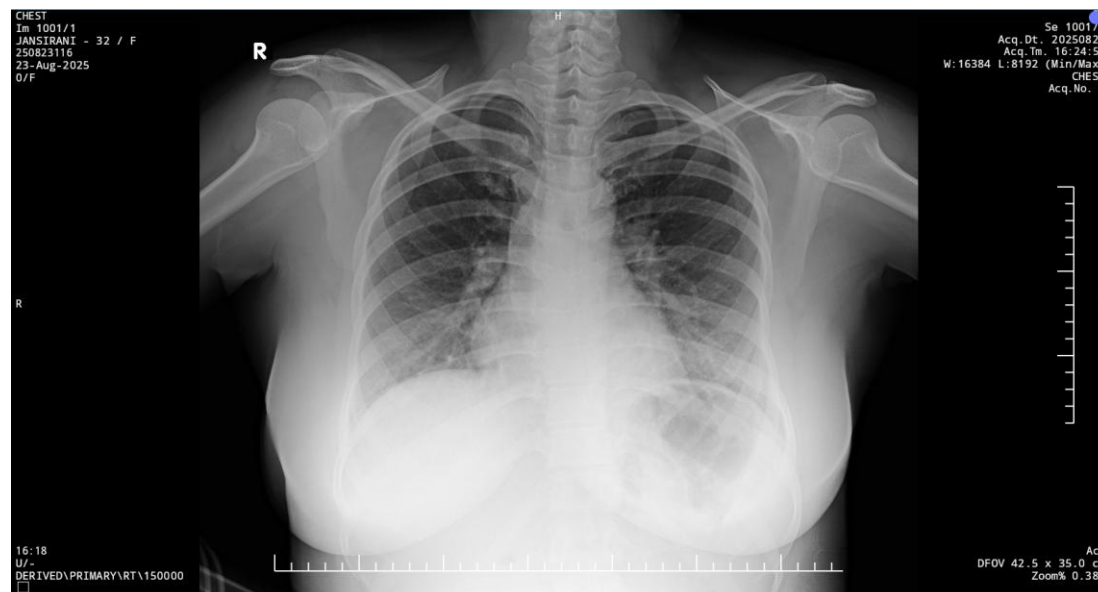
H- Showed chest X-Ray- PA view with increased bronchovascular markings in bilateral lung fields
